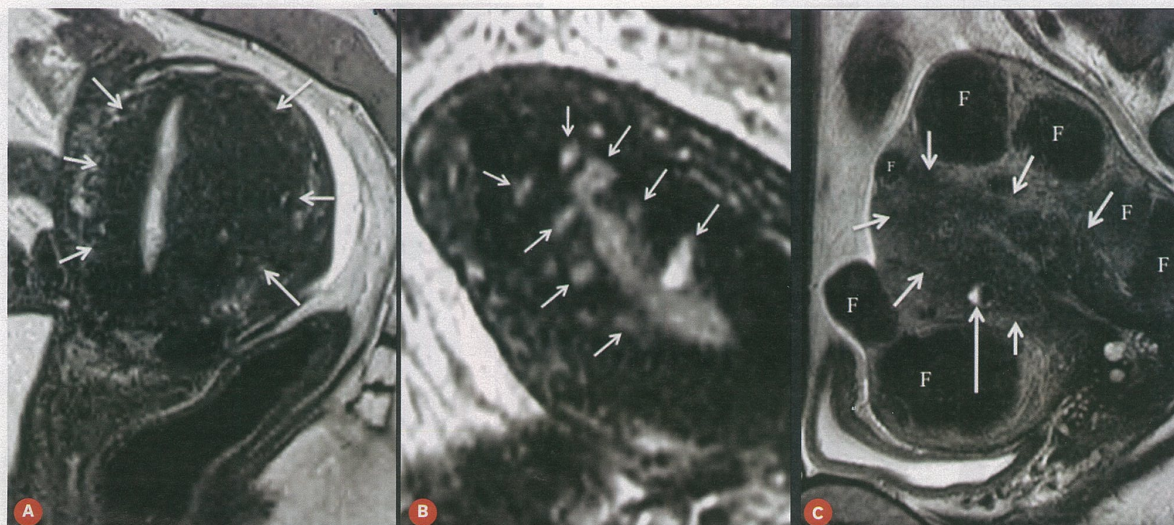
MRI of adenomyosis.
